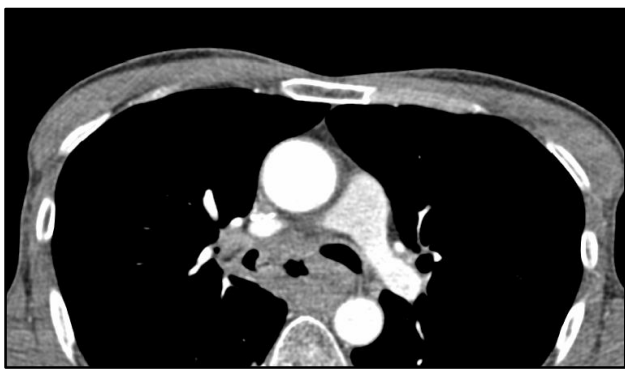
Contrast-Enhanced CT Chest Showing Circumferential Proximal Oesophageal Thickening in a Case of Carcinoma Oesophagus with a Hypodense Track Extending to the Right Main Bronchus - Oesophago-Bronchial Fistula
